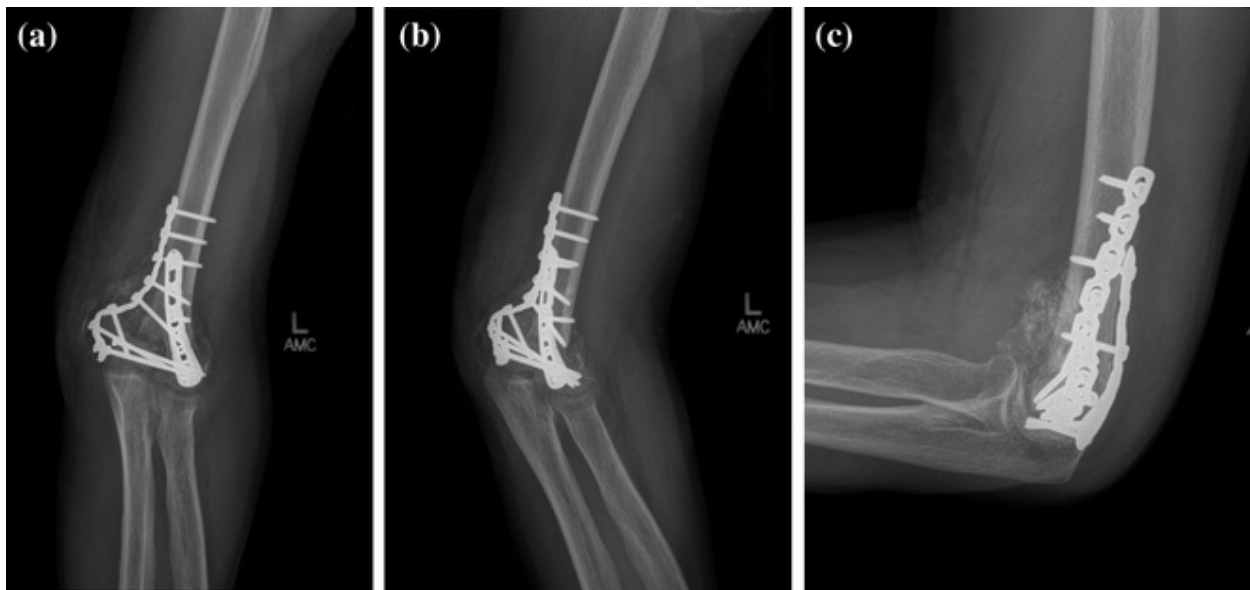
Anteroposterior (a), oblique (b), and lateral (c) radiographs after removal of medial implants, reduction of the medial condyle, and revision open reduction and internal fixation with an iliac crest bone graft
